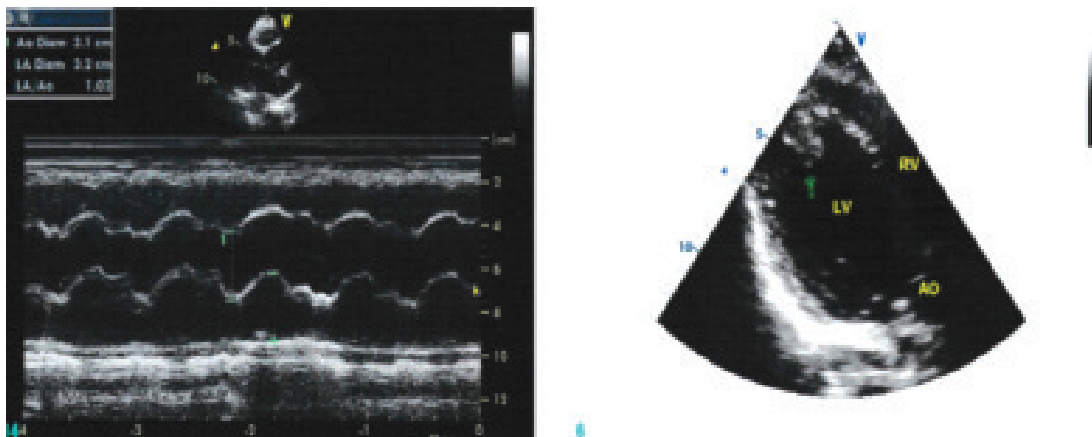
Transthoracic echocardiography showing a pedunculated heterogeneous mass (arrow) in the left ventricle.
